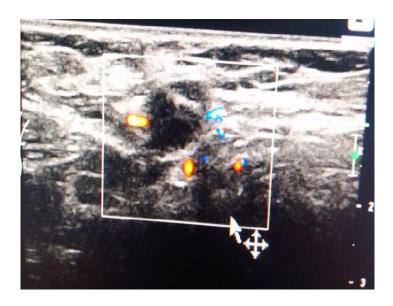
Left breast ultrasound: hypoechoic mass containing foci of calcification surrounding architectural distortion with possible extension into an adjacent dilated duct invading underlying muscle.
